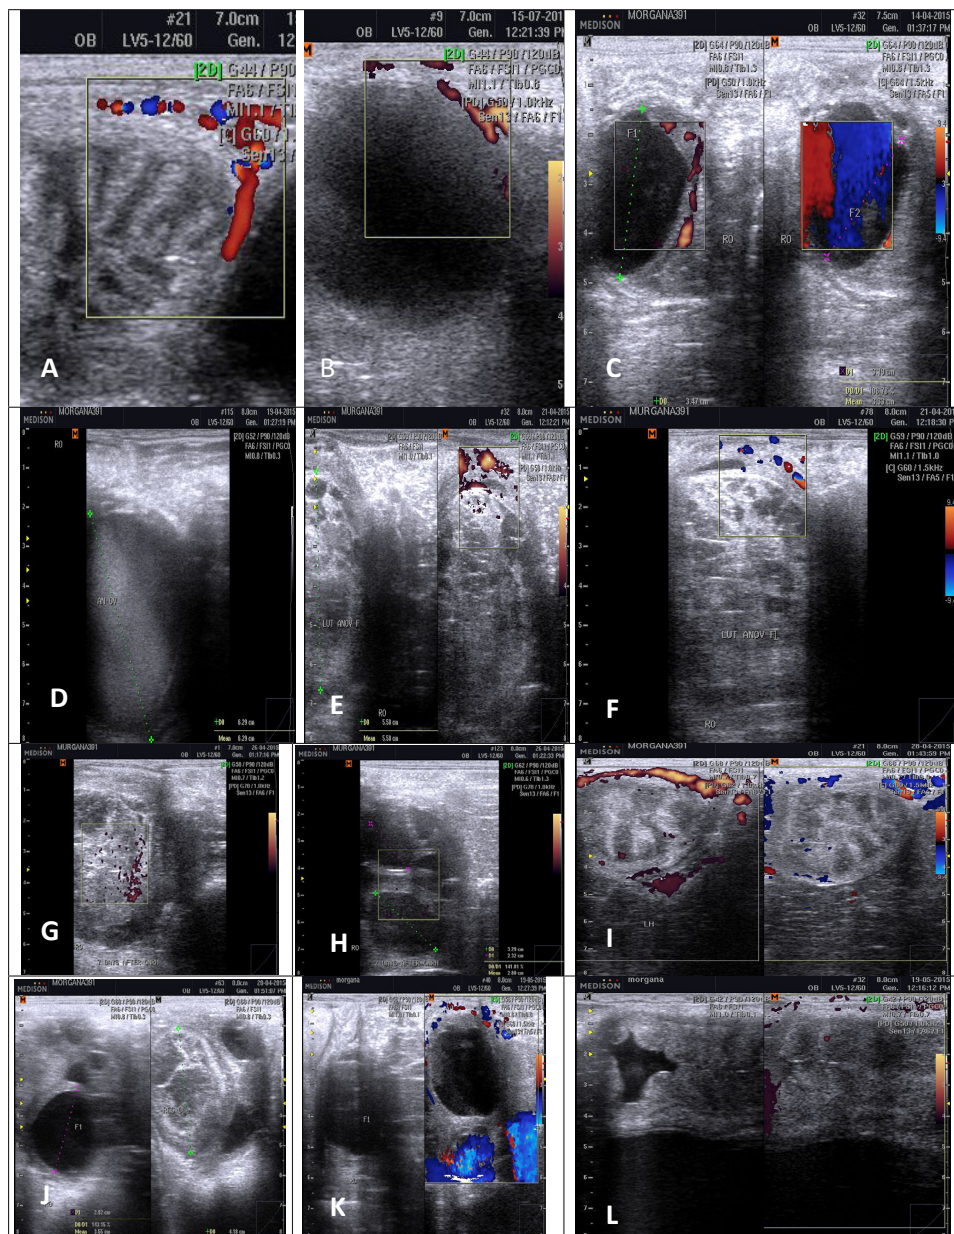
Ultrasonogram of uterine oedema: A – with colour Doppler during development of untreated AnOV follicle, B – with power Doppler. C – AnOV with colour (right) and power (left) Doppler 5 days before anovulation. D – day 0 – AnOV with diameter >60 mm treated with GnRH. E – day 2 after GnRH with power and F – colour Doppler. G – day 7 after GnRH with power and H – next
